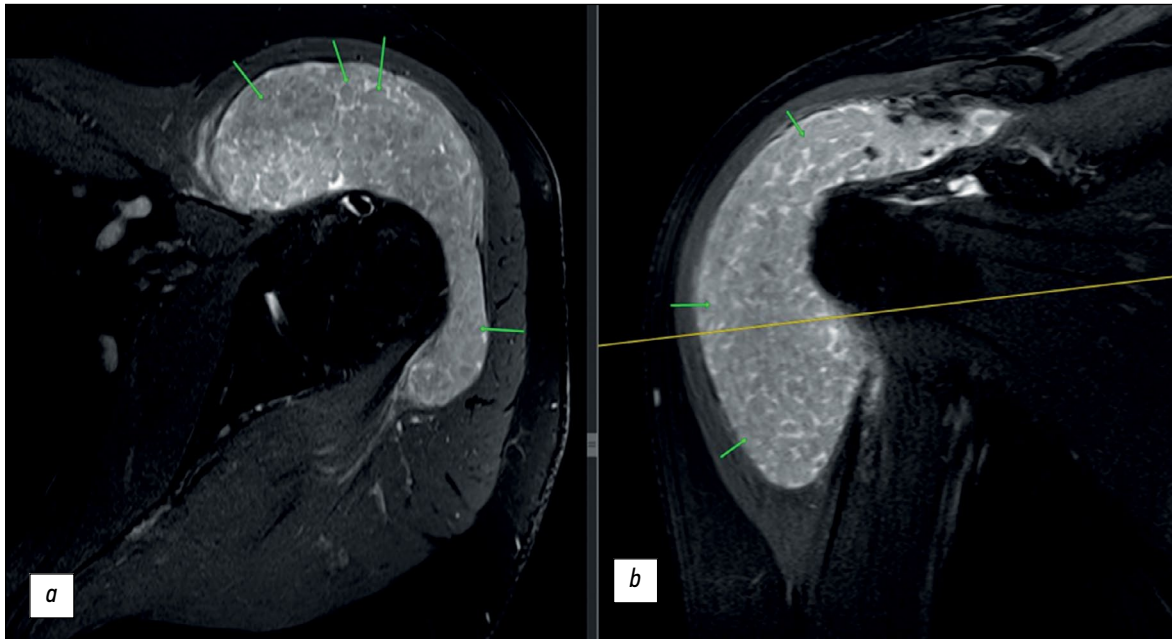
Magnetic resonance imaging of the left shoulder joint, T2-weighted images with fat suppression: *a*, transverse view; *b*, coronal view. Small structures within the synovial sacs are indicated by arrows.
